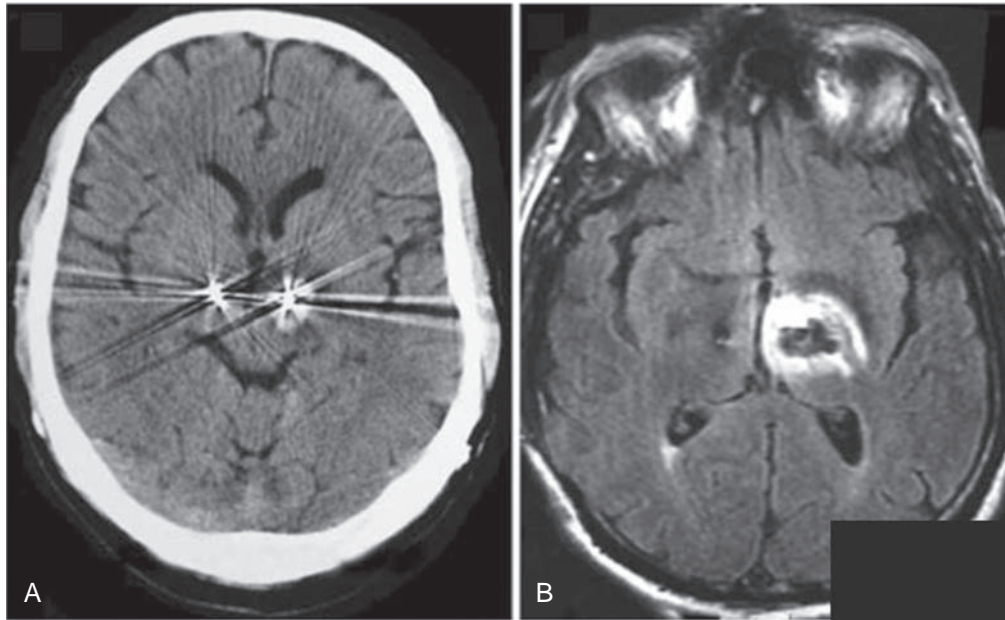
Adverse event due to failure to adhere to medical device product guidelines. Tissue damage (brain hemorrhage) as a result of radiofrequency heating at the left deep brain stimulator (DBS) lead tip that occurred during a routine MR examination of the lumbar spine. The CT (A) and MRI (B) images of the brain were acquired immediately after a lumbar spine MR scan performed on a 1.0 T MR scanner using the body coil to transmit and a surface coil to receive, and a relatively SAR aggressive imaging protocol. Alternatively, the DBS device manufacturers specified the MR conditions under which MRI can be accomplished safely for patients implanted with this device as a 1.5 T scanner using a transmit receive head coil and head SAR levels at or below 0.1 W/kg. (From Henderson JM, Tkach JA, Phillips M, et al. *Permanent neurological deficit related to magnetic resonance imaging in a patient with implanted deep brain stimulation electrodes for Parkinson's disease: case report*. *Neurosurgery*. 2005;57:1063.)
